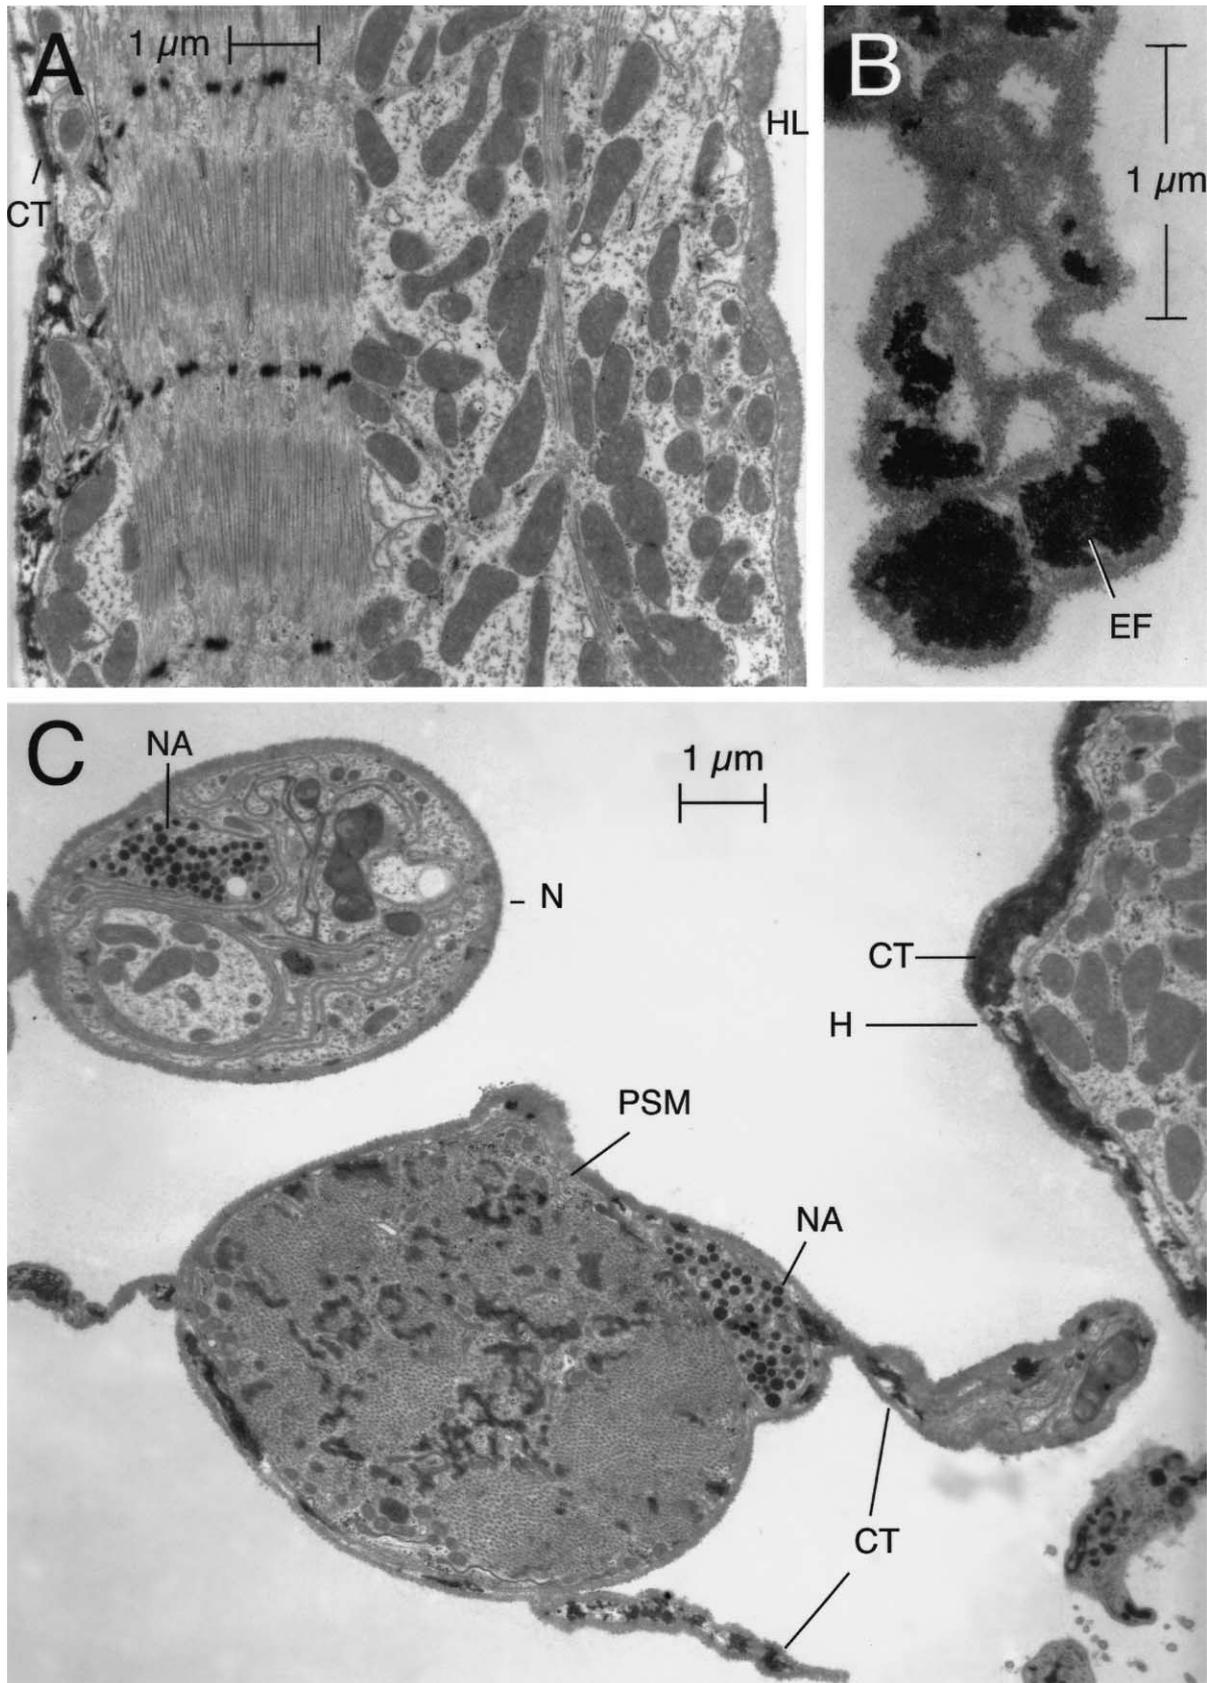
Muscle cells of anterior heart wall and pericardial septum. TEM. (a) Cross-section of large heart chamber with spirally oriented muscle fibrils. The lumen face (HL) is lined by dense basement membrane, the hemocoel face is covered with basement membrane containing bundles of elastic fibers (CT). (b) Cross-section of extracellular connective tissue strand connecting heart with surface layer of the pericardial muscle cells. (c) Cross-section of pericardial septum muscle (PSM) and heart nerve (N) with neurosecretory axons (NA). CT = connective tissue; EF = elastic fibers; H = heart; HL = heart lumen.
